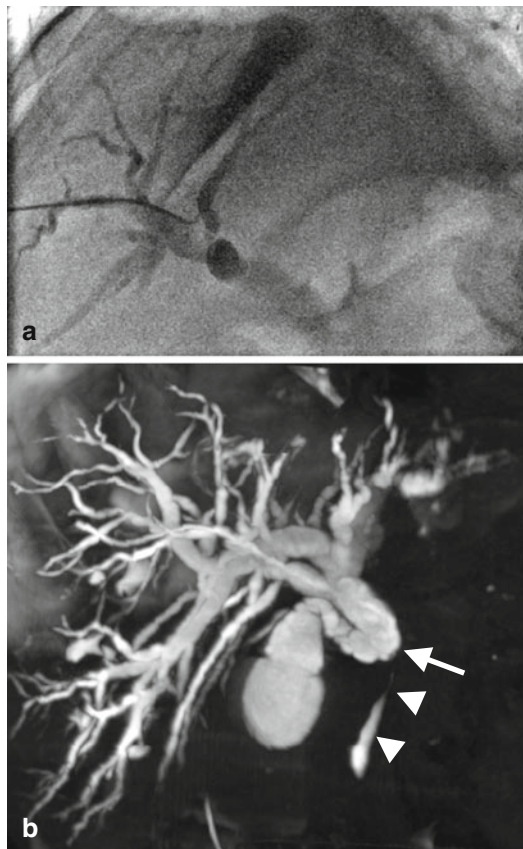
(a, b) PTC and direct C-arm CT cholangiography. (a) Fluoroscopic image after puncture of a right hepatic bile duct, contrast injection, and insertion of a guidewire. (b) C-arm CT cholangiography after injection of diluted contrast material through the drainage catheter shows the subtotal stenosis of the common bile duct (arrow) followed by a filiform stenosis of the subsequent segment (arrowhead) caused by a tumor in the pancreas head. Due to the high endoluminal contrast, a high window level allows for a clear delineation of the small bile duct branches even with MIP
